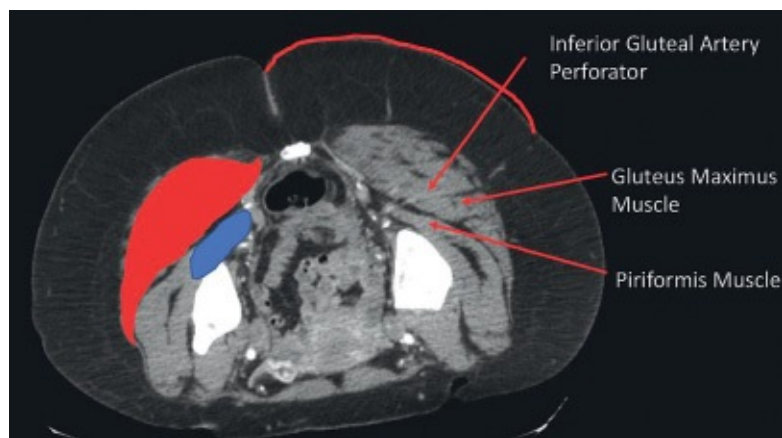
• Locations of IGAP perforator on axial CT scan
